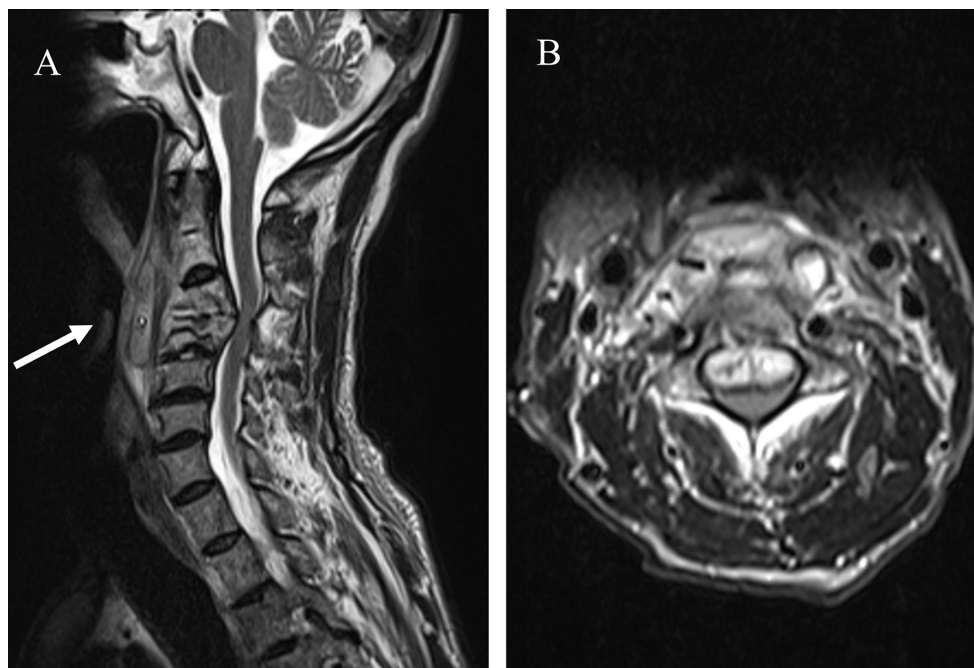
MRI of the cervical spine following ultrasound puncture and abscess reduction. A, Sagittal view. B, Axial view.
